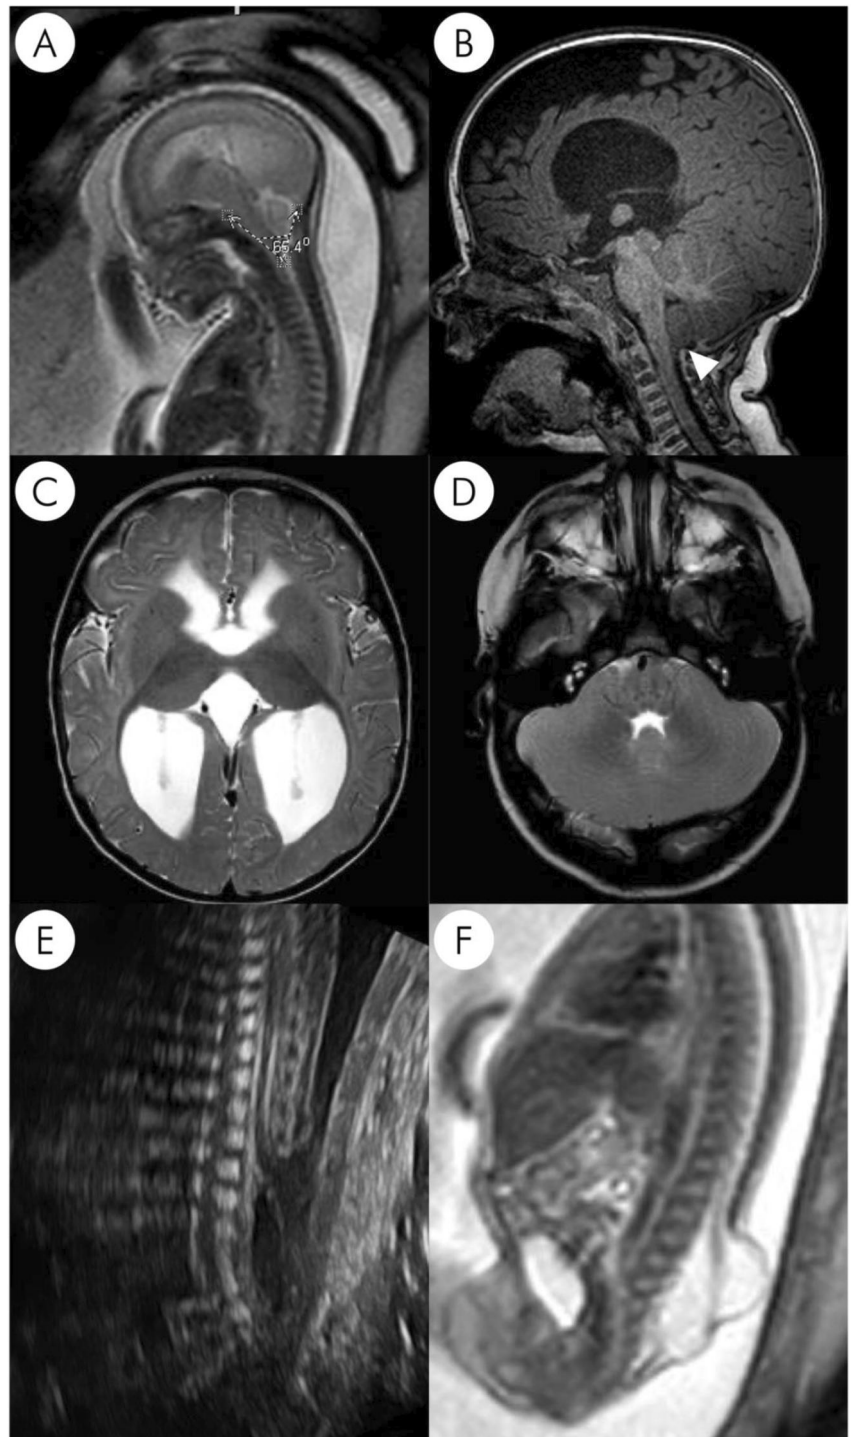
A–F: Pre- and postnatal images of posterior fossa and spine (case 11): (A) Sagittal T2-weighted MRI of the brain and upper spinal cord at 21.6 days GA shows a small posterior fossa with downward herniation of the inferior vermis and cerebellar tonsils below the foramen magnum (FM) with effacement of the fourth ventricle and cisterna magna. The Clivus-supraocciput angle measures 65°. (B–D) postnatal sagittal T1-weighted and axial T2-weighted MRI of the same child confirm the prenatal diagnosis of a Chiari II malformation with effaced basal cisterns, mild downward displacement of cerebellar tonsils and inferior vermis into the upper cervical spinal canal (arrowhead), embracement of the brainstem by the anteriorly extending cerebellar hemispheres, supratentorial hydrocephalus and prominent interthalamic adhesion. (E + F) prenatal sagittal US and sagittal T2-weighted fetal MRI performed at 21.6 days GA show the large spinal defect with dorsal protrusion of the low positioned spinal cord through the osseous defect. The dilated terminal ventricle and central canal partially herniated through the dorsal defect into a meningocele leading to “sac within a sac” image, typical for MCC.
